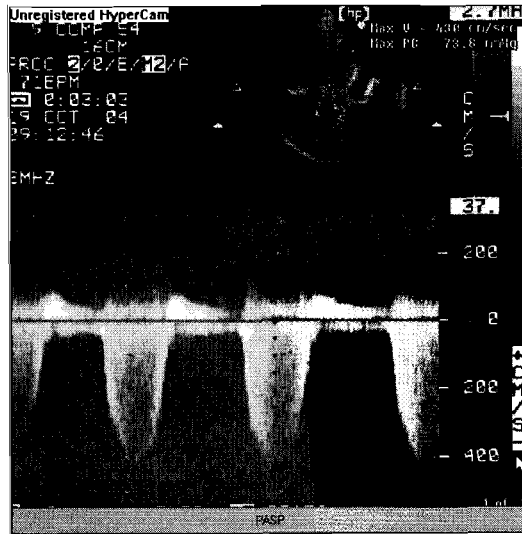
Continuous wave Doppler across TR jet giving peak velocity of TR jet. This gives PASP estimation (see text)
